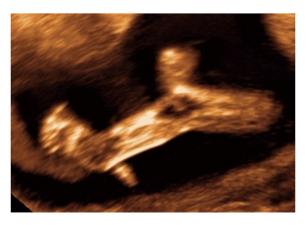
Prenatal ultrasound scan at 12 + 6 weeks of gestation showing club foot.
